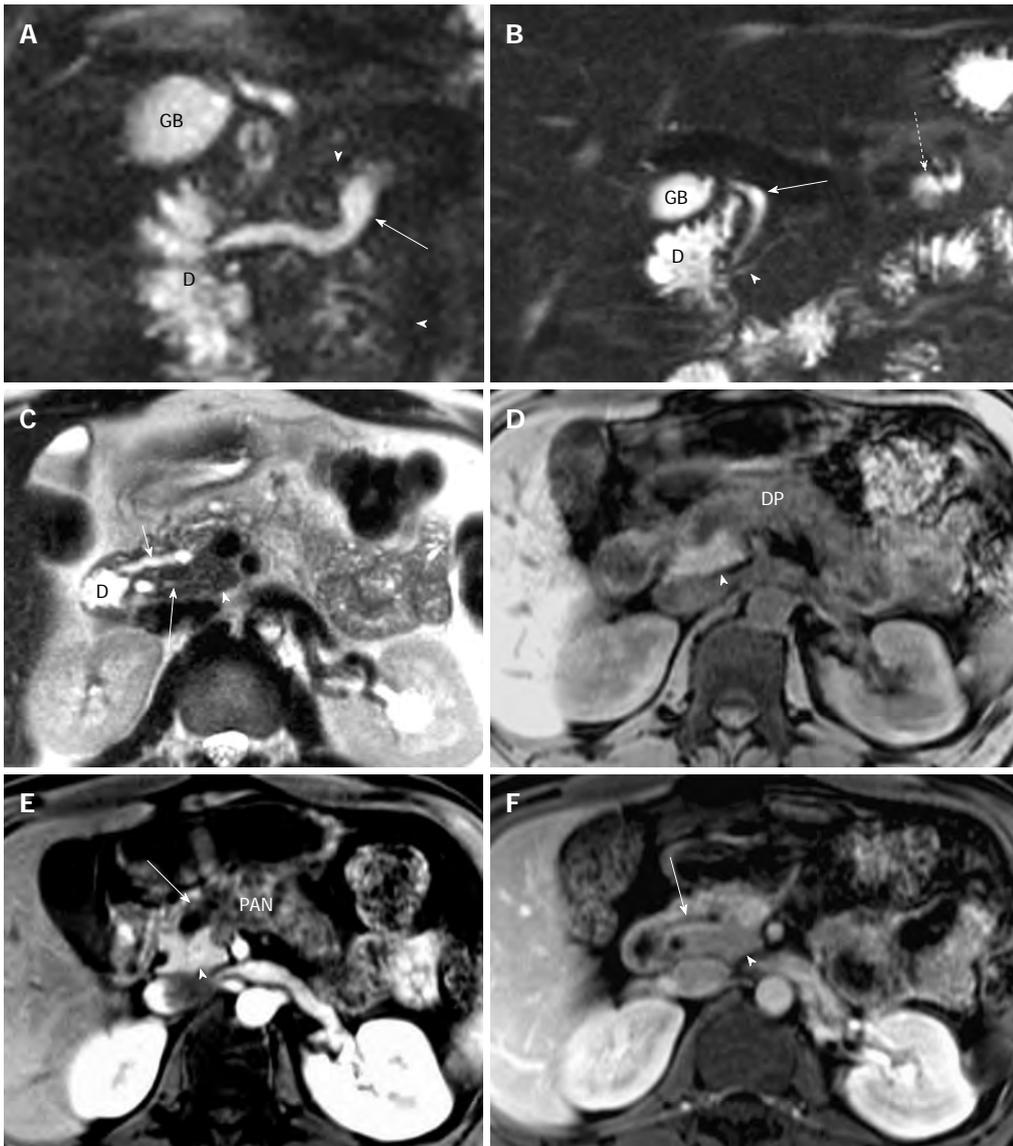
Magnetic resonance cholangiopancreatography and magnetic resonance imaging of recurrent acute pancreatitis only involving the dorsal pancreas in a 43-year-old man. A: Coronal-oblique, thin-section half-Fourier rapid acquisition with relaxation enhancement magnetic resonance (RARE-MR) cholangiogram [infinite/95 (effective), 3-mm section thickness] shows marked dilatation (1 cm in diameter) of duct of Santorini (arrow) with apparent side branch ectasia (arrowheads). The gallbladder (GB) and the duodenum (D) are demonstrated clearly; B: Coronal-oblique, thin-section half-Fourier RARE MR cholangiogram [infinite/95 (effective), 3-mm section thickness] shows normal common bile duct (arrow) and ventral duct (arrowhead) of pancreas. The cystic changes secondary to pancreatitis in the pancreatic tail (dotted arrow) is shown while the GB and duodenum (D) appear normal; C: Axial T2WI shows dilatation and irregularity of duct of Santorini (short arrow) which enters the duodenum (D) *via* minor papilla. The ventral duct (solid arrow) and the pancreatic uncinata (arrowhead) are normal in size and signal intensity while the anterior portion of pancreatic head is abnormal with elevation of signal intensity; D: Axial precontrast T1WI SPGR shows that the pancreatic uncinata (arrowhead) is normal in size and signal intensity and the dorsal pancreas (DP) is abnormal with decreased T1 signal intensity and the swelling of the parenchyma; E: Axial T1WI SPGR after administration of Gd-DTPA at arterial phase shows normal enhancement of the pancreatic uncinata (arrowhead) and the enhancement of dorsal pancreas (PAN) is remarkably compromised with duct dilatation (arrow) and cystic changes; F: Axial T1WI SPGR at portal venous phase after administration of Gd-DTPA shows normal wash-out of contrast material in pancreatic uncinata (arrowhead) and delayed enhancement of the anterior portion of pancreatic head with dilatation of duct of Santorini (arrow).
